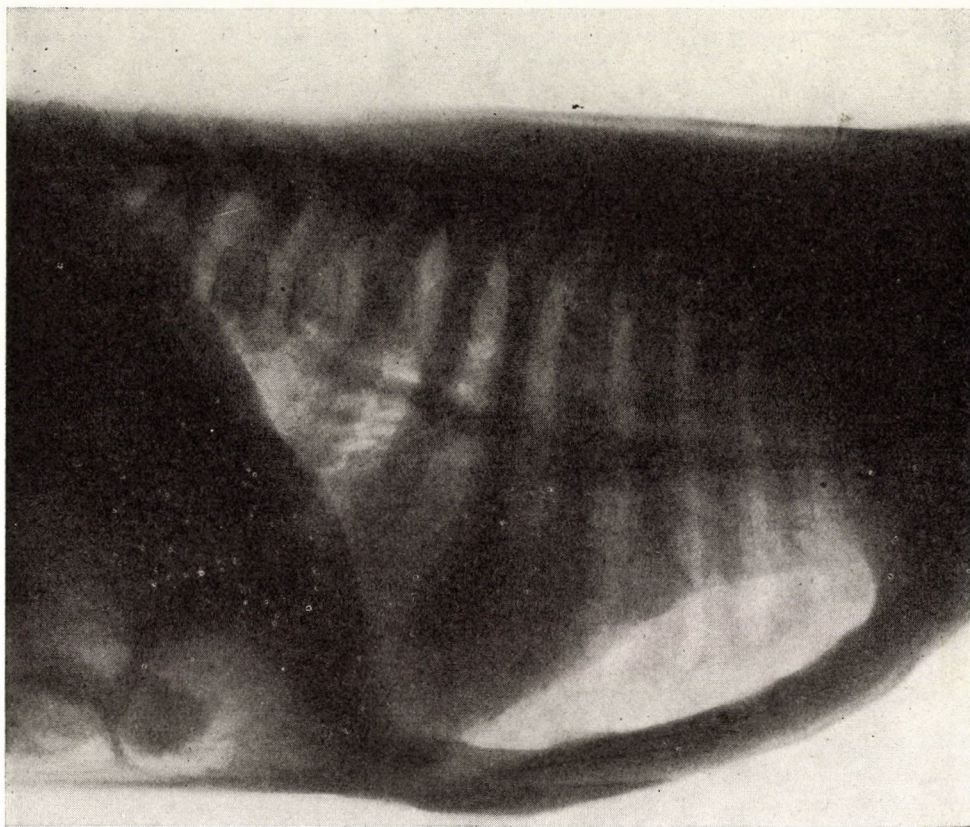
Case 2 (K. M.) Lateral chest radiograph at 5 months of age. The lung bulges into the mediastinum, the dome of the diaphragm is displaced downward
